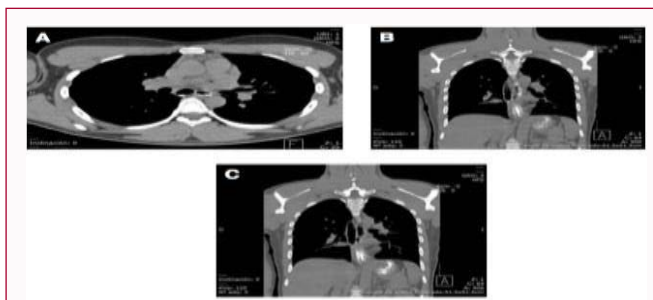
Computed tomography (CT) of the chest. (A) Axial plane of the CT scan at the subcarinal level showing to the tubular communicating esophageal duplication. (B&C) Coronal plane of the CT scan showing the esophageal duplications communicating with the stomach.
